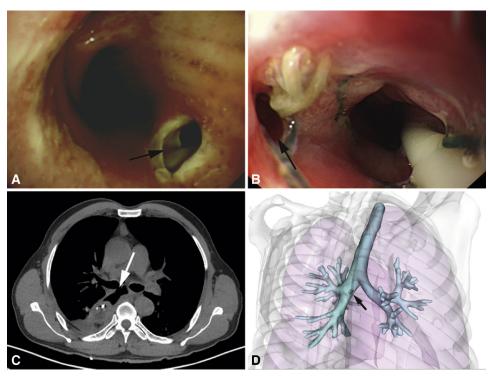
A 54-year-old man with thoracic stomach-right bronchus fistula before stenting. A, Bronchoscopy showed that the fistula located at the right main bronchus (*black arrow*). B, Gastroscopy showed that the fistula was in thoracic stomach (*black arrow*). C, Axial CT image showed that the right main bronchus communicated with the thoracic stomach (*white arrow*). D, 3D reconstruction based on CT imaging showed the patient's airway with fistula, which was close to the carina and the opening of the right upper lobe bronchus (*black arrow*).
